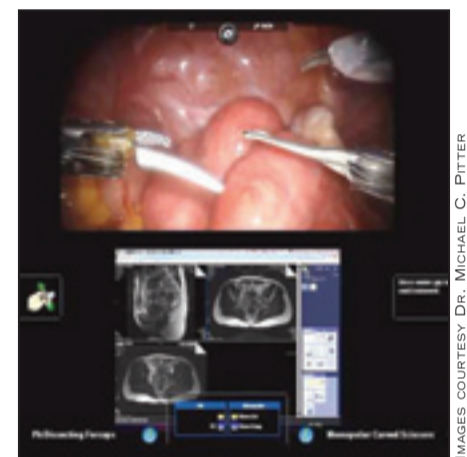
(left): Below the endoscopic view of the fibroid uterus (top), MR images are superimposed in the surgeon's console viewer. The upper left MR image is a sagittal pelvic view indicating the presence of fibroids (left to right) in the posterior fundal, submucosal, and posterior midportion of the uterus. The upper right and lower left images are axial views showing fibroids (top to bottom) in the anterior left, submucosal left midportion, and posterior midportion of the uterus. In Image 2, the relative size of the images are adjusted to the surgeon's needs.
